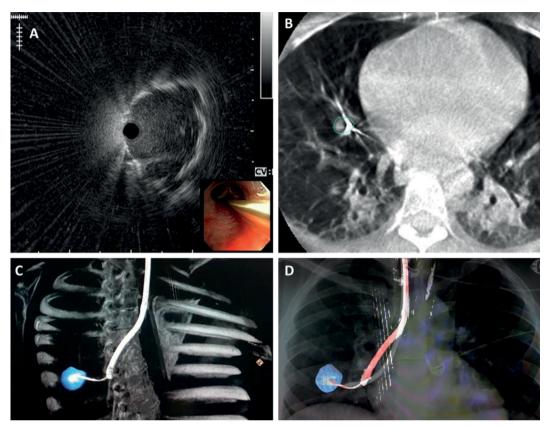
(A) RP-EBUS to identify the correct nodule position; (B) Cone Beam CT to confirm the probe position; (C) 3D reconstruction of cone beam CT to generate a pathway off-set to be used in the 3D radioscopy; (D) 3D radioscopy with augmented fluoroscopy and real-time position confirmation.
